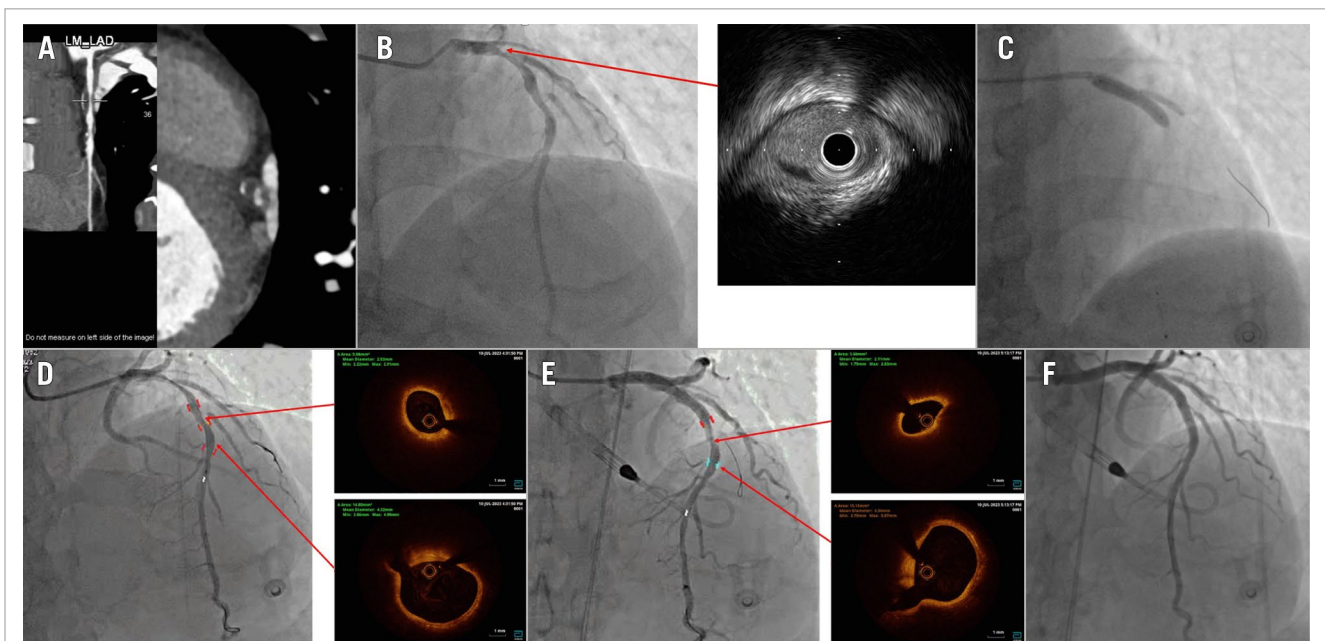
Post-stenting longitudinal plaque migration. A) Preprocedural coronary CT angiography showed a significant “apple-core” lipid-rich plaque in the pLAD. B) Proximal LAD 80-90% lesion with moderate mLAD disease. IVUS of the LAD showed significant lipid-rich atherosclerotic plaque. C) Proximal LAD stenting with a MJBT at the D1 after distal protection with a SpiderFX device. D) Pre-stenting measurements: MLA of the mLAD moderate lesion was 5.08 mm². The distal reference at the septal branch was 14.86 mm². E) Post-LAD stenting, the MLA at the mLAD was 3.60 mm². The comparable distal reference vessel area measured 15.15 mm² after IC nitroglycerine, making coronary spasm unlikely; changes are likely due to longitudinal migration of lipid-rich plaque. F) Satisfactory final angiographic results after IC nifedipine/adrenaline and mechanical circulatory support with Impella CP. CT: computed tomography; IC: intracoronary; IVUS: intravascular ultrasound; LAD: left anterior descending artery; MJBT: modified jailed balloon technique; MLA: minimum lumen area; mLAD: mid-LAD; pLAD: proximal LAD
